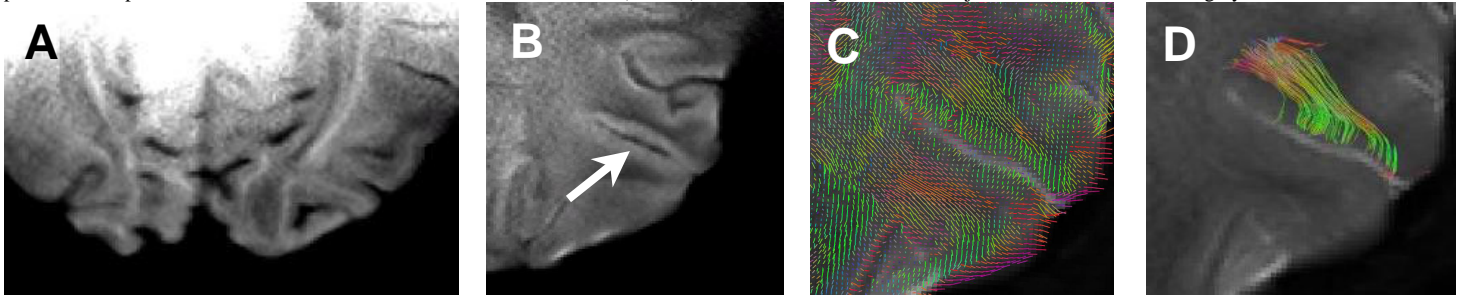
A) and B): High resolution ($580 \times 580 \mu\text{m}^2$ in plane) diffusion weighted images of the occipital lobe obtained with the micro-coil array using SENSE at 3 Tesla. The diffusion weighting was $b = 1400$ s/mm² in A and $b = 1000$ s/mm² in B, respectively. C): Color-coded main diffusion vectors superimposed on T2-weighted ($b = 0$) image. D): Reconstructed fibers of a seed area located anterior to the sulcus. C, D reflect the same (magnified) sulcus as shown in B (arrow).
